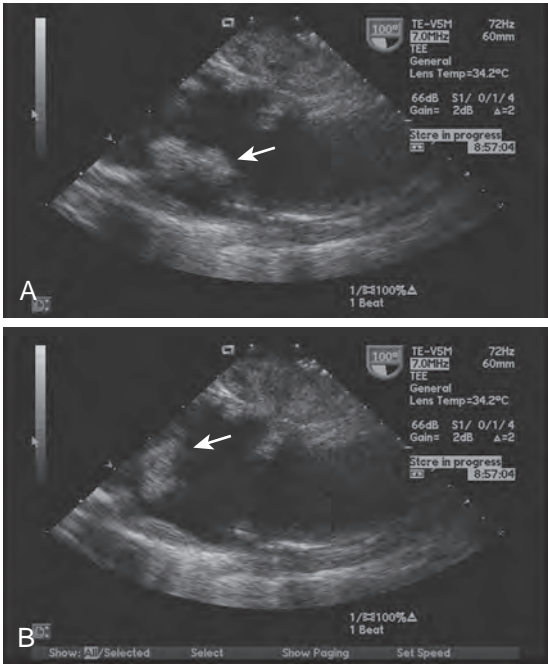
Transesophageal echocardiographic (TEE) long-axis images of the descending thoracic aorta demonstrating severe atherosclerotic disease with atheroma protruding into the vessel lumen. Images obtained in diastole (A) and in systole (B) demonstrated a large mobile atheroma (arrow) that may represent an atheromatous plaque that has ruptured and detached from the aortic wall.
